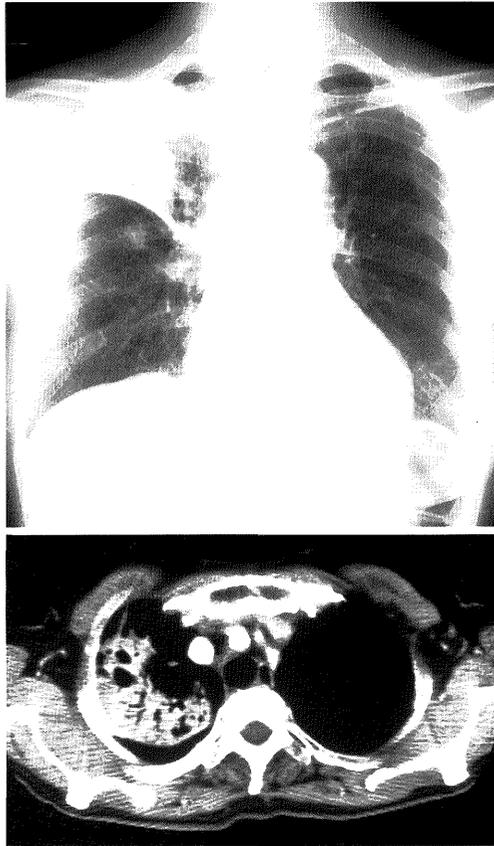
Chest X-ray and CT film on admission (May, 1990) show shadows of an alveolar pattern in the right upper lobe and right S⁶.
